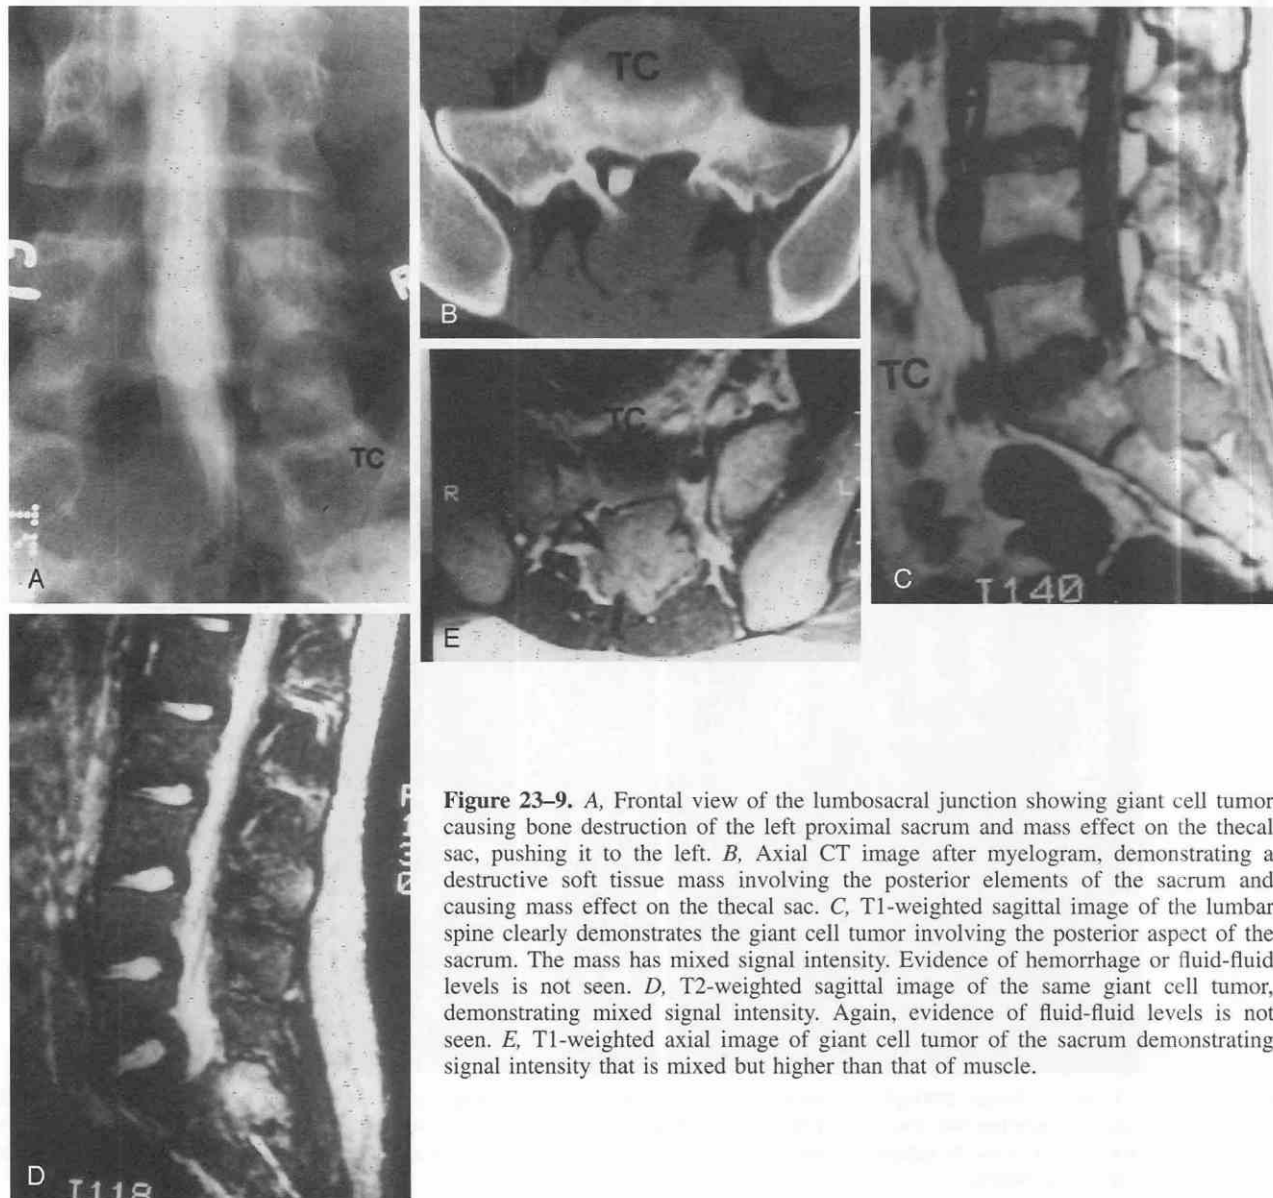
A, Frontal view of the lumbosacral junction showing giant cell tumor causing bone destruction of the left proximal sacrum and mass effect on the thecal sac, pushing it to the left. B, Axial CT image after myelogram, demonstrating a destructive soft tissue mass involving the posterior elements of the sacrum and causing mass effect on the thecal sac. C, T1-weighted sagittal image of the lumbar spine clearly demonstrates the giant cell tumor involving the posterior aspect of the sacrum. The mass has mixed signal intensity. Evidence of hemorrhage or fluid-fluid levels is not seen. D, T2-weighted sagittal image of the same giant cell tumor, demonstrating mixed signal intensity. Again, evidence of fluid-fluid levels is not seen. E, T1-weighted axial image of giant cell tumor of the sacrum demonstrating signal intensity that is mixed but higher than that of muscle.
